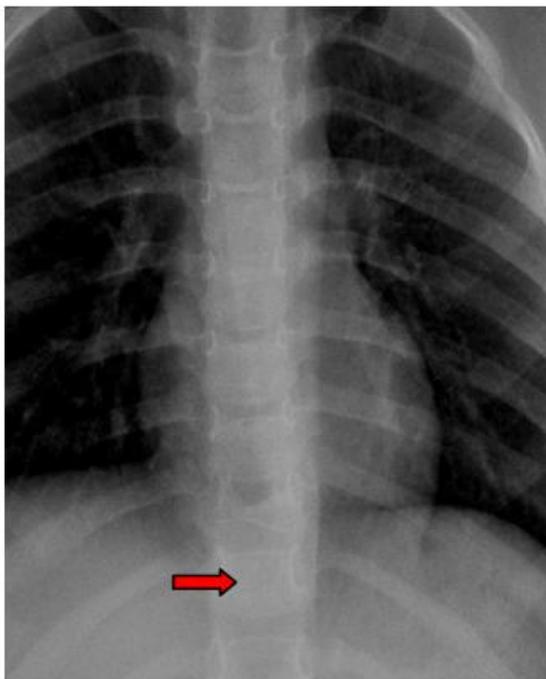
Plain radiograph showing collapse of D9 Vertebra
